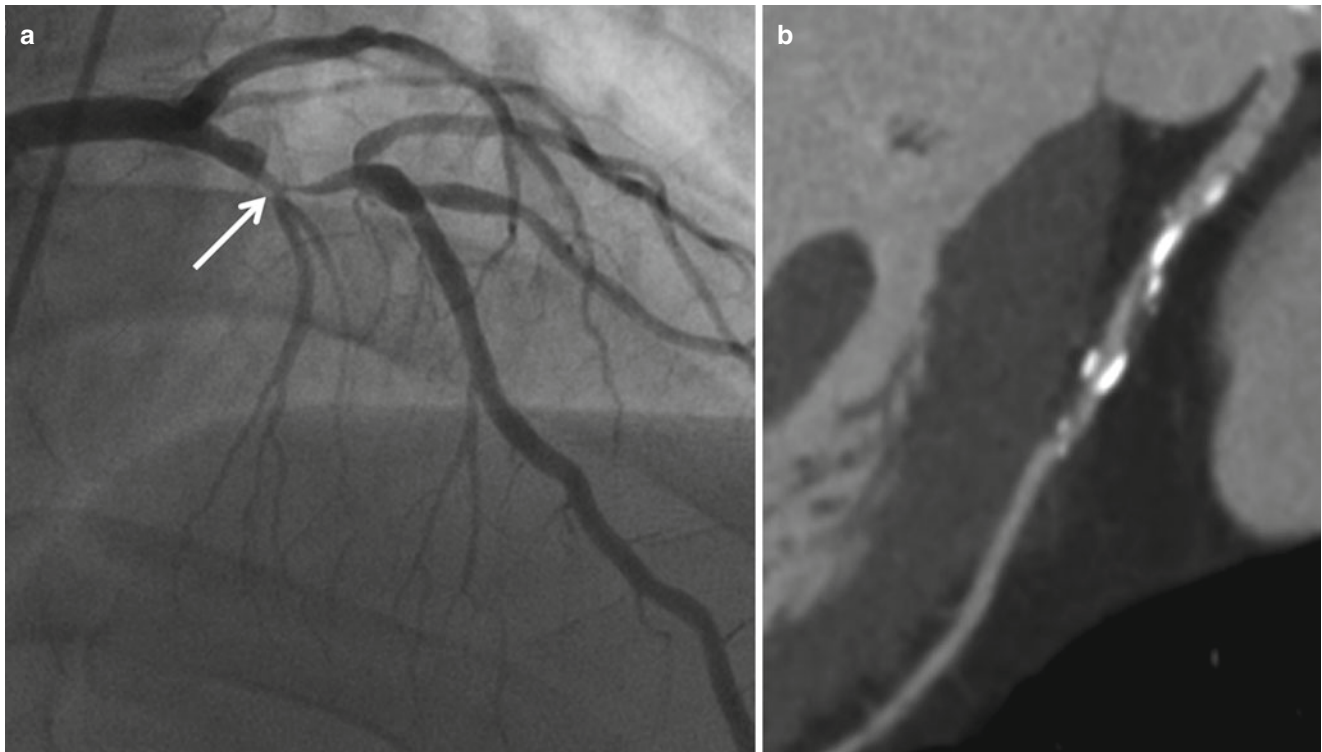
Invasive coronary angiography and coronary computed tomographic angiography (CCTA) of the left anterior descending artery (LAD). (a) Invasive angiogram shows significant coronary artery
